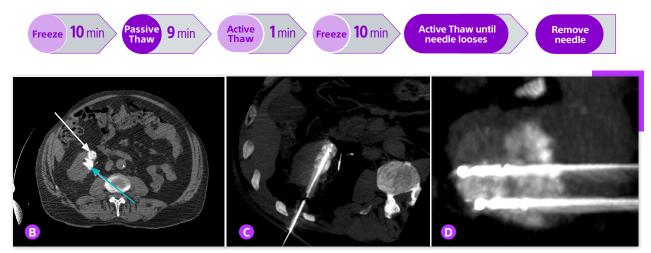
Non-contrast CT (axial view) immediately after super-selective injection IceSphere™ 1.5 needle inserted into the of Lipiodol<sup>™</sup> in tumour-feeding arteries upper pole of the renal tumour shows 'marking' of the target tumour (white arrow) and some collected Lipiodol™ in the adjacent renal parenchyma (blue arrow)
